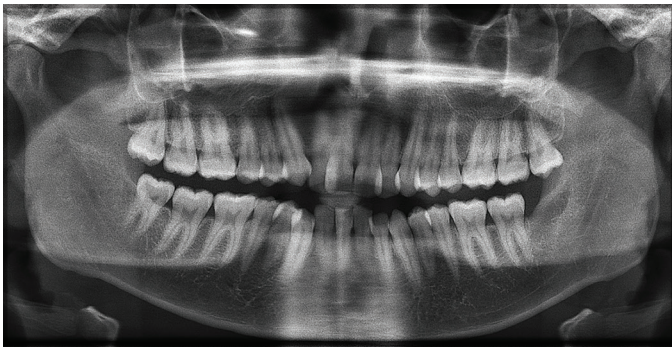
Postoperative panoramic radiograph confirming successful fragment retrieval.
